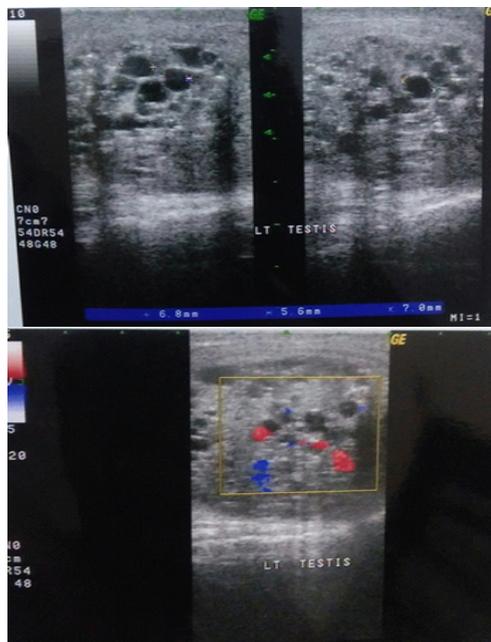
Non Seminomatous Germ cell Tumor showing Heterogenous echotextured lesion with cystic areas within, colour Doppler showing raised vascularity.
